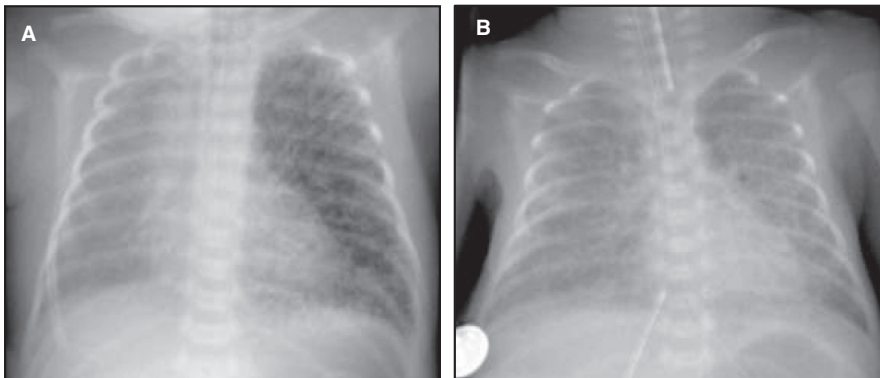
Example of chest X-ray with PIE. Anterior-posterior chest X-ray with diagnosed PIE (A, unilateral left; B, bilateral)
